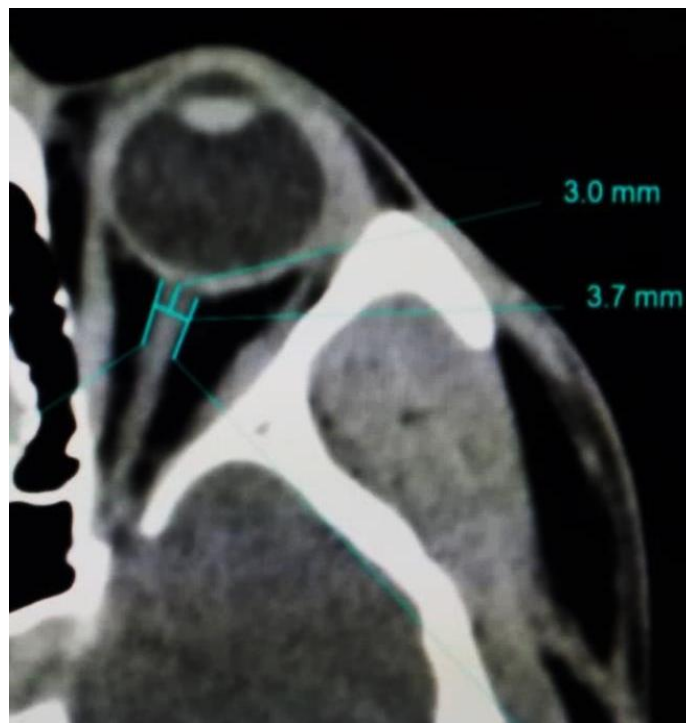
ONSD at 3mm retrobulbar, axial CT scan
